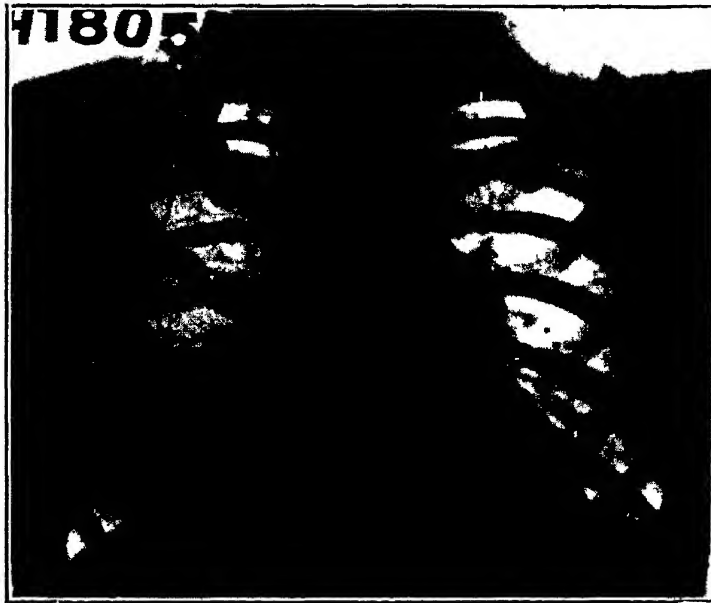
Case 6, July 1, 1937. Essentially negative lung fields on admission. Child admitted because of chorea. Mantoux test given on date of this roentgenogram. (Lincoln and Grethmann J. Pediat.)
